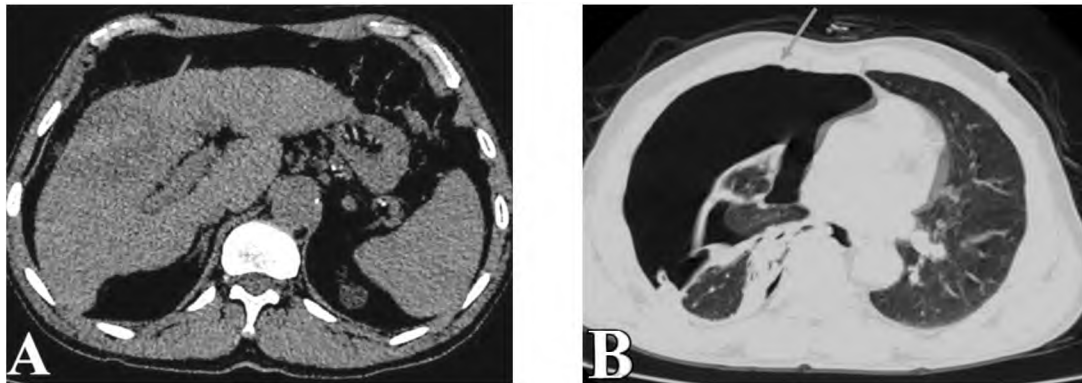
Male patient aged 73 years old with hepatitis C cirrhosis. Triphasic CT of the abdomen revealed a single HCC. (A): Non-contrast CT of the abdomen showing a well defined focal lesion in the right lobe segment V denoting the previous ablation of the hepatic focal lesion (Red arrow). (B): Non-contrast CT chest revealed pneumothorax of the right lung 5 days post-MWA of the right liver lobe (Segment V) HCC (Yellow arrows).
